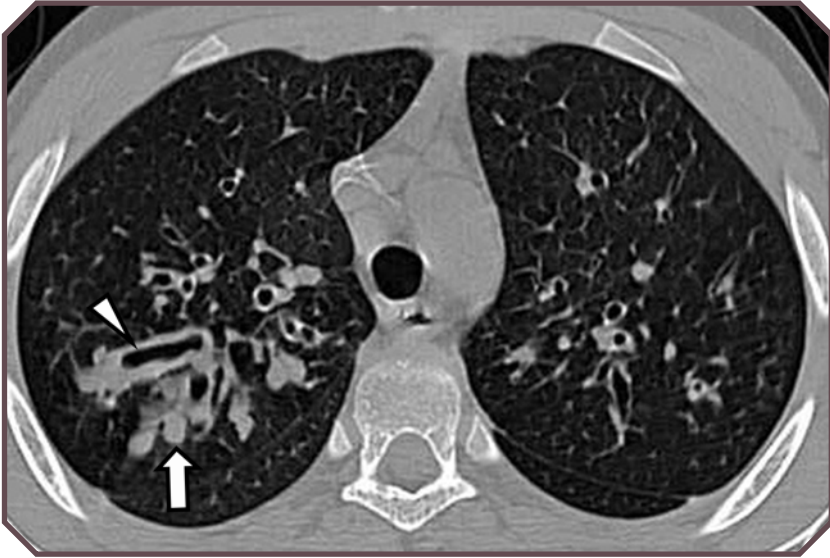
Cystic fibrosis (CF) in a 12-year-old girl. Axial unenhanced computed tomographic image demonstrates extensive peribronchial thickening, mucous plugging (arrow), and bronchiectasis (arrowhead), which are typical of CF.
